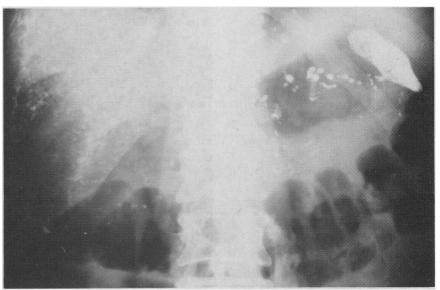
Plain film of abdomen, showing fine metallic densities, characteristic of Thorotrast deposition, in irregularly shaped liver, small spleen and lymph nodes.
